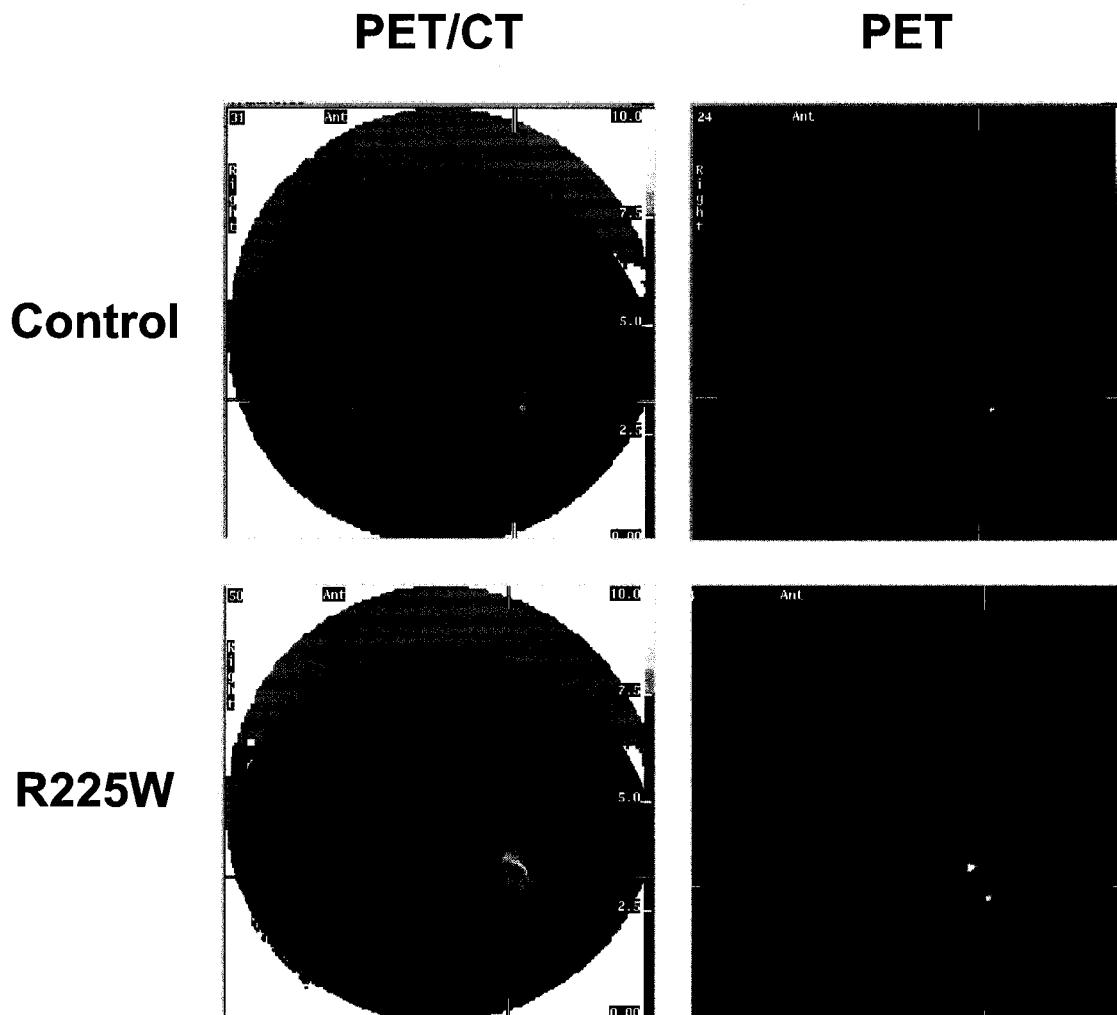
PET/CT and PET images of cross section of thighs in R225W carrier and matched control following exercise intervention. FDG indicated by colour intensity scale on right of each image (colour at top of scale indicates highest concentration of FDG). Anterior thigh: top; posterior thigh: bottom. Resting leg on left, exercised leg on right.
